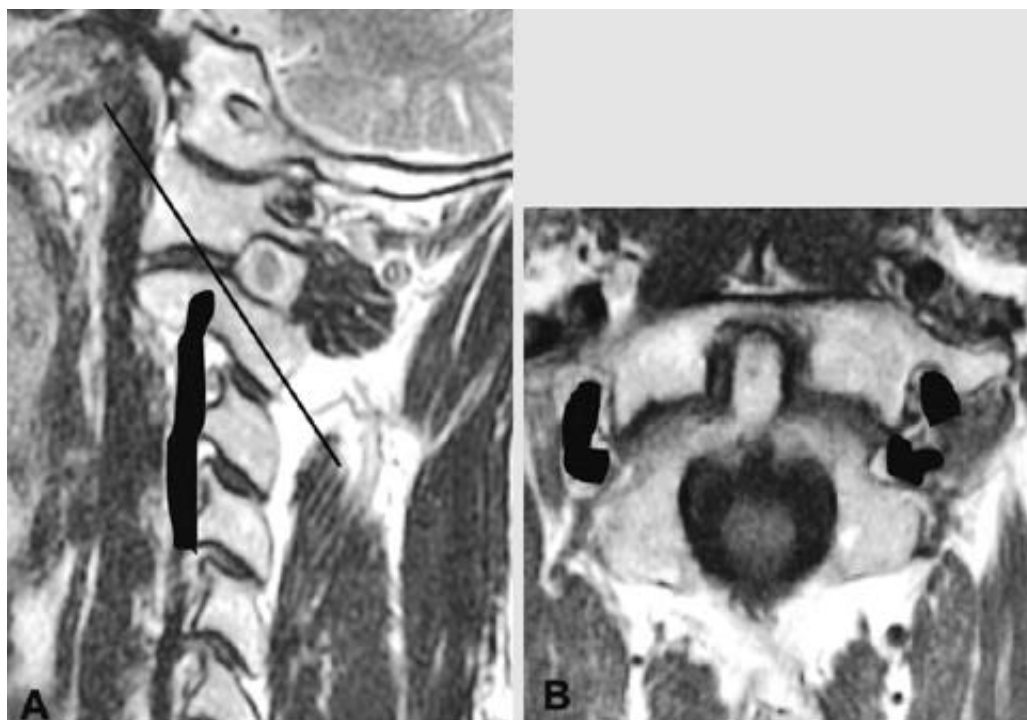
A sagittal MR image of the cervical spine transecting center of the C1-2 joint. Black line is an ideal trajectory of the C1-2 transarticular screw. Vertebral artery is marked as black color (A). An oblique axial image of the C1-2 joint obtained along the ideal trajectory line on the sagittal MR image. Vertebral artery is marked as black color (B).
